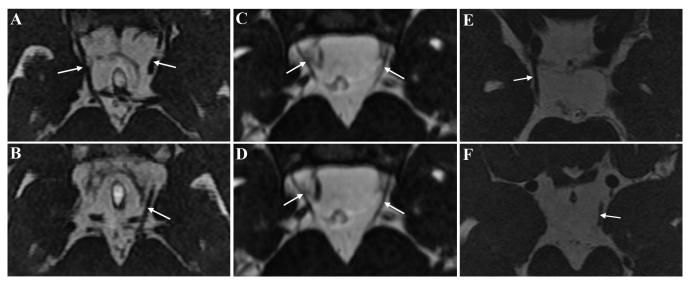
Imaging of the oculomotor nerves. A–B: Bilateral oculomotor nerves demonstrated by the axial magnetic resonance imaging (MRI) of a normal control. C–D: The axial MRI indicates bilateral hypoplastic oculomotor nerves in patient II:1. E–F: Patient II:2 presented hypoplasia similar to that of patient II:1, according to the axial MRI.
